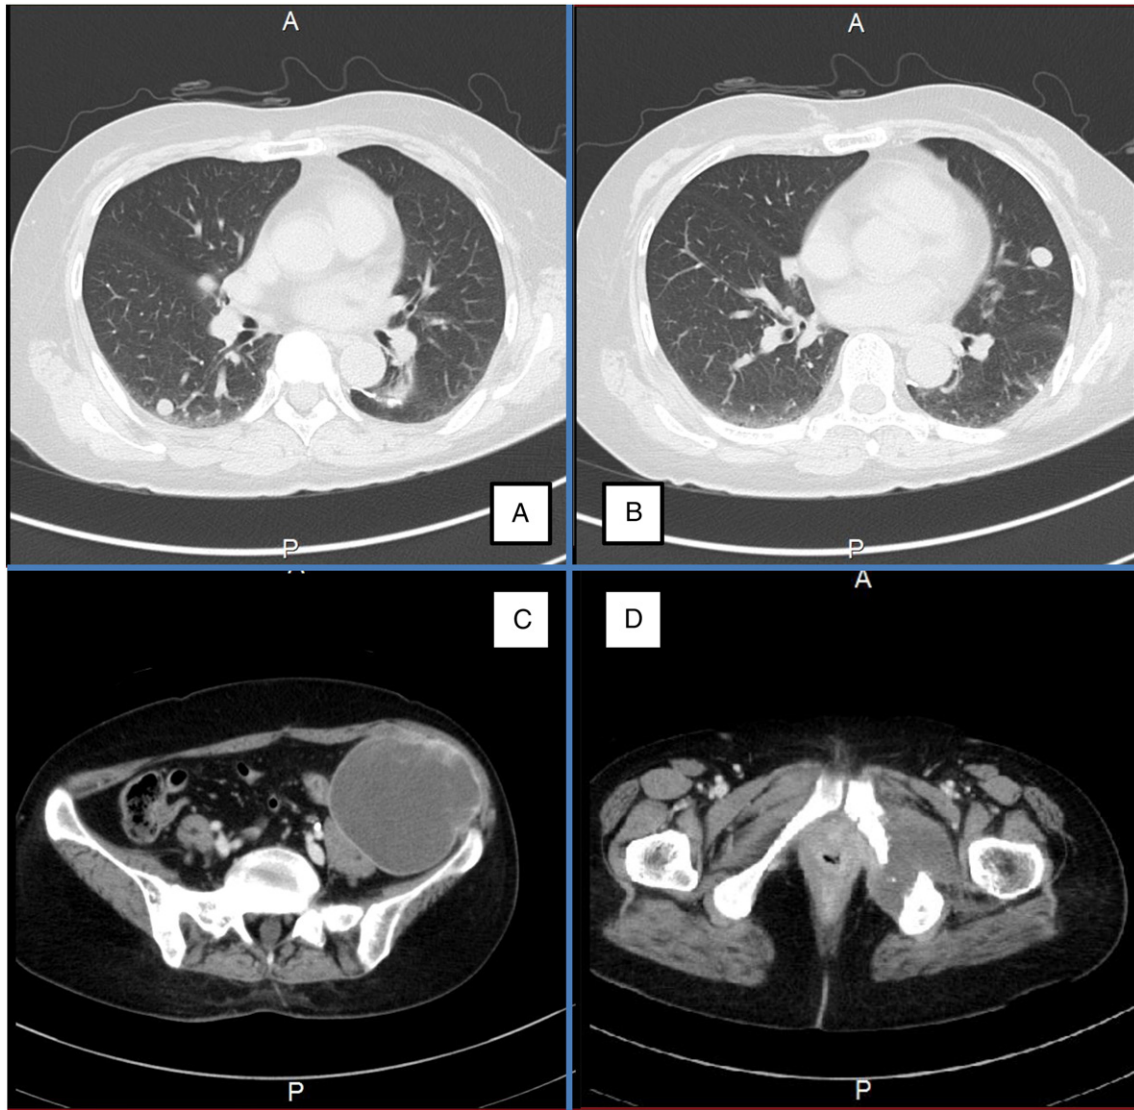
CT images of the lung and pelvis. A and B: Multiple small metastatic lesions in bilateral lung fields on chest CT. C: A cystic lesion in the left pelvis. D: A 5-cm tumor and a lytic lesion of the pubic bone.
